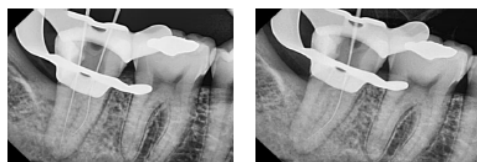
Periapical radiograph to confirmed the working length.
